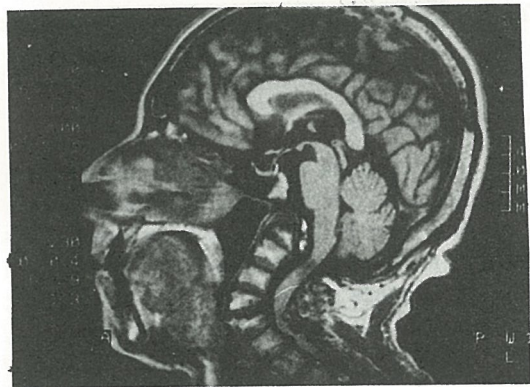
Sagittal T1-weighted MR image showing severe cord compression on midcervical level, deformed and rudimented odontoid process and C1 arch, some compression to the pontomedullary junction. Note that C5-6 level is just behind the tongue.
